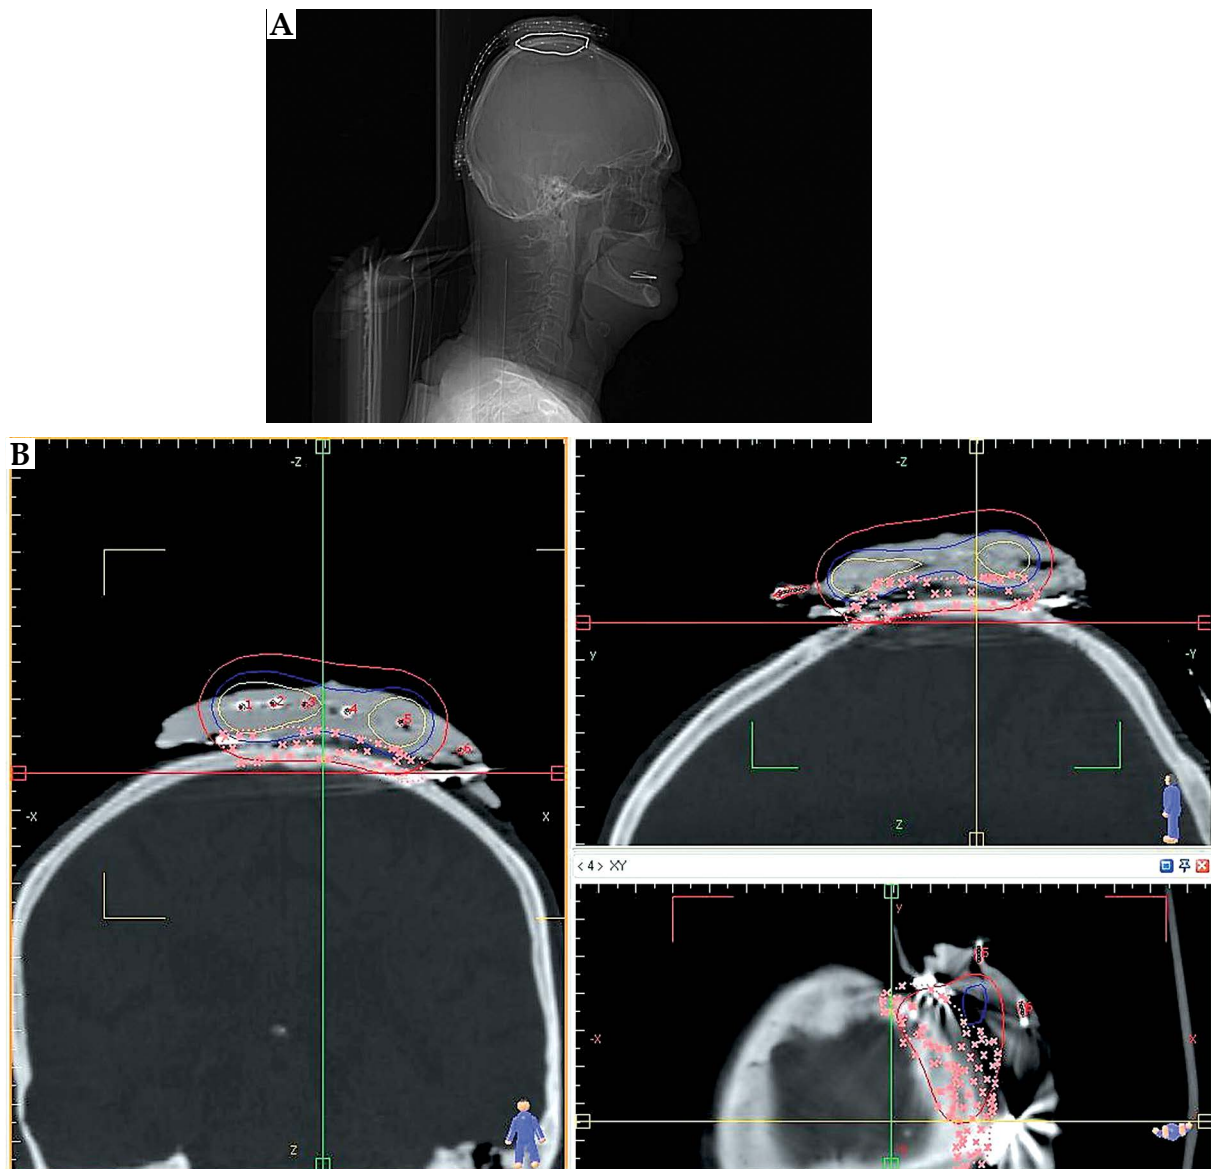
A) The digital reconstruction radiograph of a patient with scalp basal cell carcinoma. The picture shows the surface mold placed over the scalp encompassing after-loading catheters. B) The dose distribution of the finalized 3D plan in axial, sagittal, and coronal planes. The yellow, blue, and the red lines represent D_{200} , D_{150} , and D_{100} , respectively. The tiny crosses show the planning target volume
